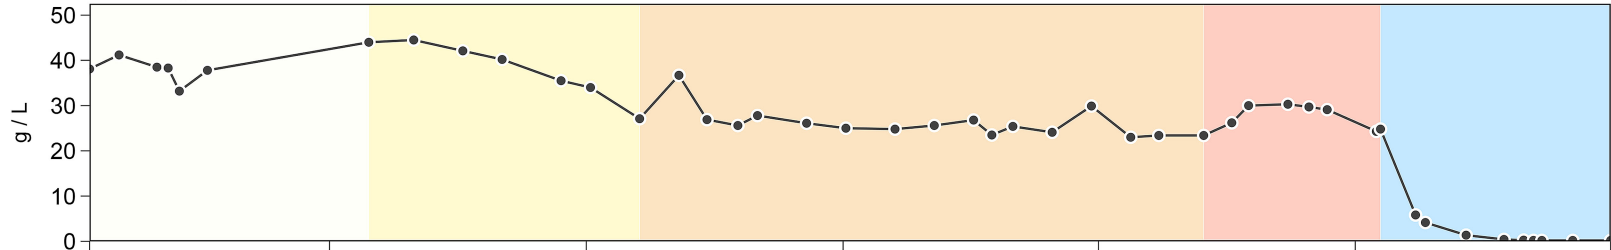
Longitudinal monitoring of serum total IgM, involved free light chain kappa concentrations during treatment course. Borte-Dexa-Ritu: bortezomib-dexamethasone-rituximab; CT: computed tomography; HSM: hepatosplenomegaly; TCP: thrombocytopenia.
